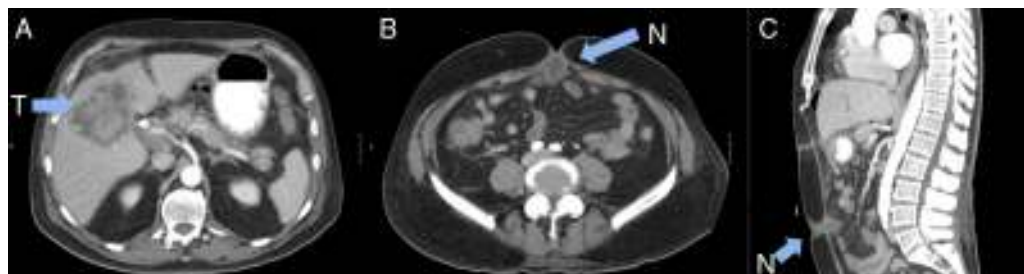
Computed tomography scan: (A) hepatic tumour. (B and C) Umbilical nodule (N).
